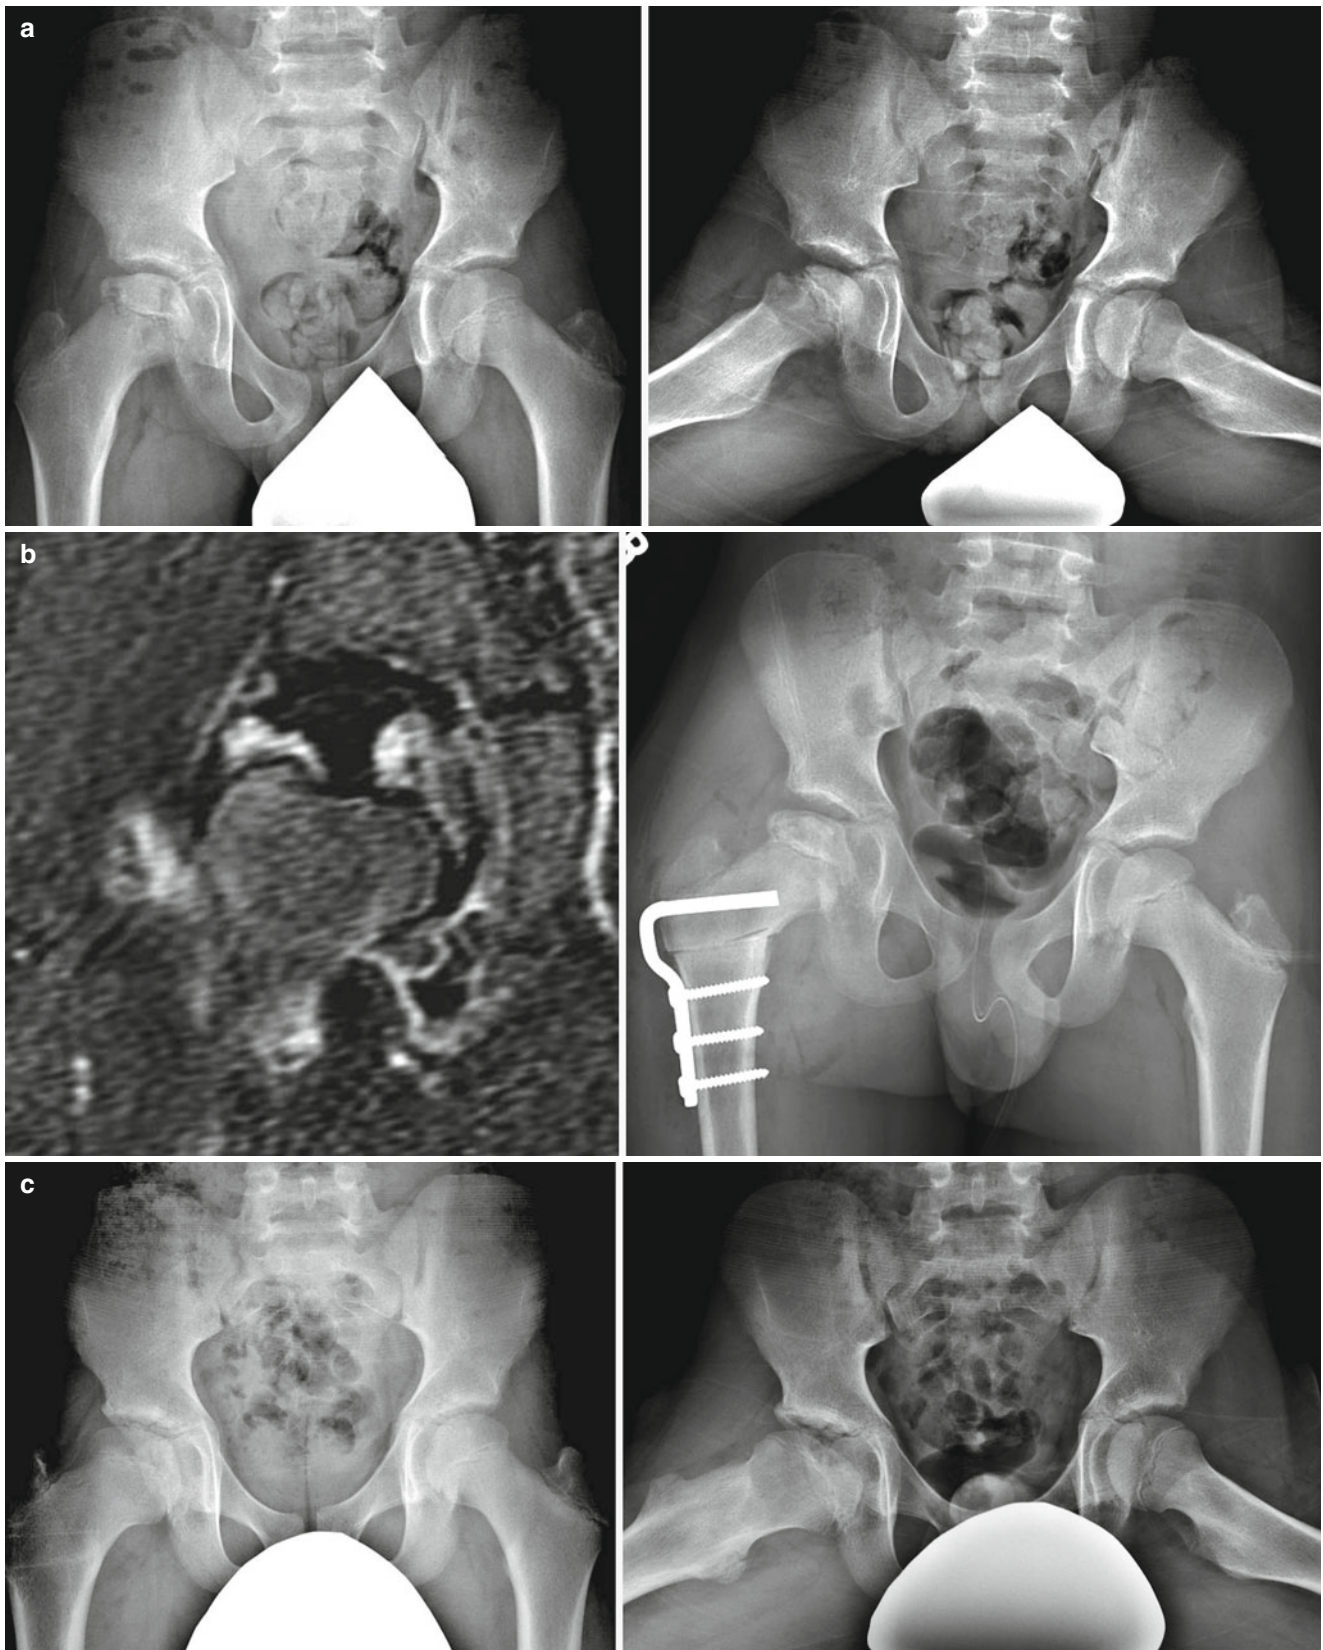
Eleven-year and 7-month-old male with right hip pain for 12 months. (a) AP pelvis and frog-leg lateral radiographs showing right hip LCPD in Waldenström stage 2A (early fragmentation stage) with some flattening of the superior region of the femoral head. The lateral pillar classification cannot be applied reliably at this stage. (b) Gadolinium-enhanced MRI with subtraction technique (perfusion
